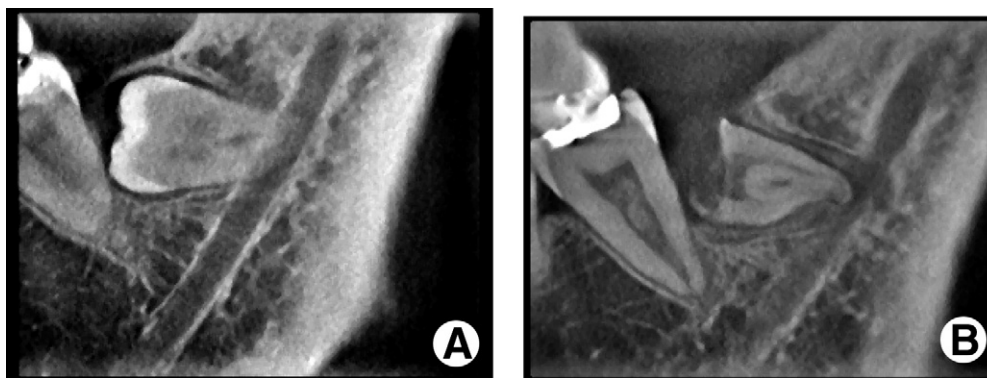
A, Preoperative dental CT image. B, Dental CT image at 3 months postoperatively.
